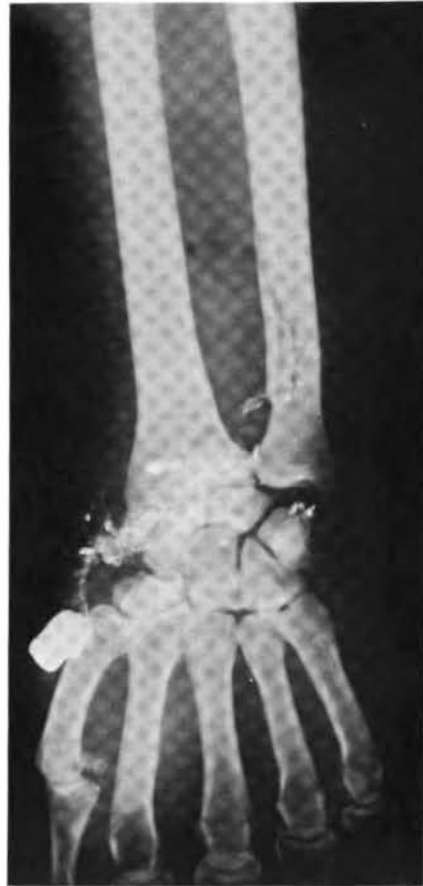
Roentgenogram of gunshot wound of wrist and forearm with early clostridial myositis. Early recognition of gas in tissues and its irregular linear spread made prompt diagnosis of the infection possible.
